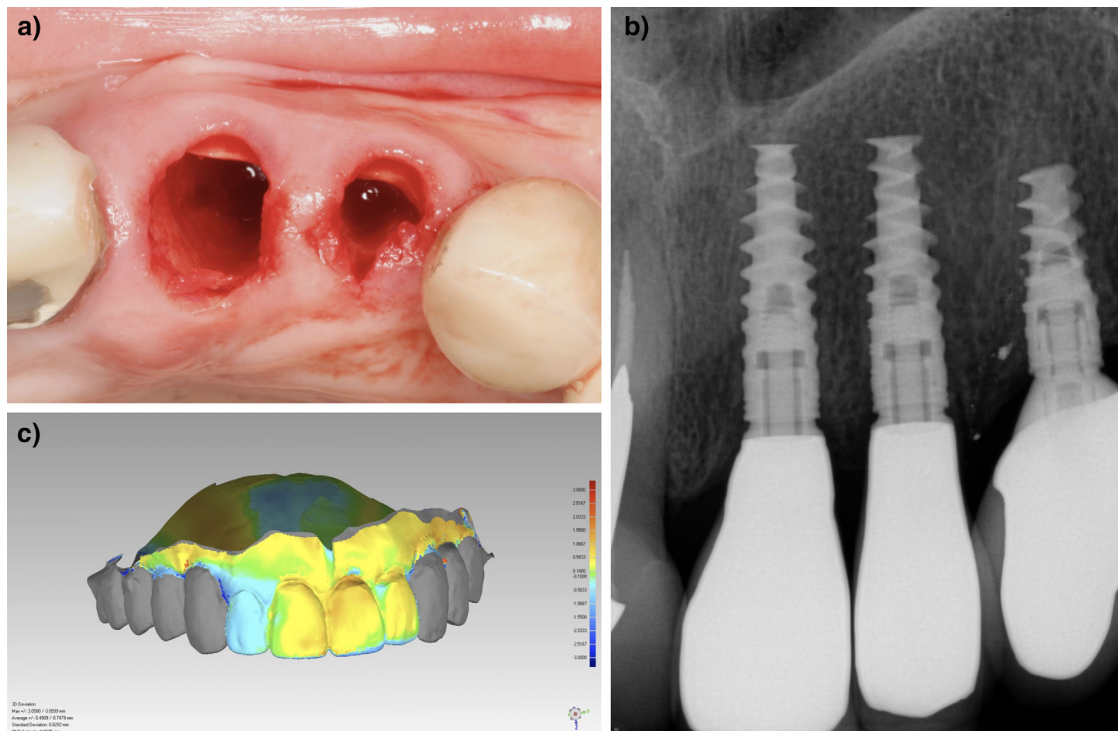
a) Root fragments just before the final shaping. b) A periapical radiograph taken at 6 years after the insertion of the final crowns on implants. c) Volumetric analysis between the digital scans of the preoperative and 6-year postoperative dental casts shows little dimension alteration.
